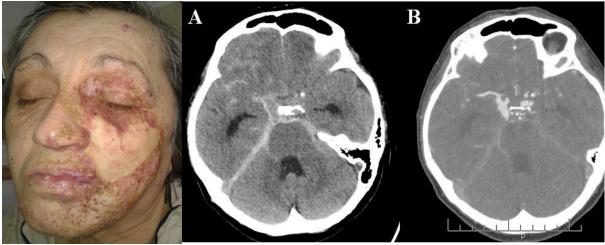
Facial Figure 137. Head CT scan with aneurysmal subarachnoid hemangioma in the hemorrhage (A). CT angiography showing vascular dysplasia and distribution of segments 2 right posterior communicating artery aneurysm (B) (from *Turliuc et al., 2017b*)
